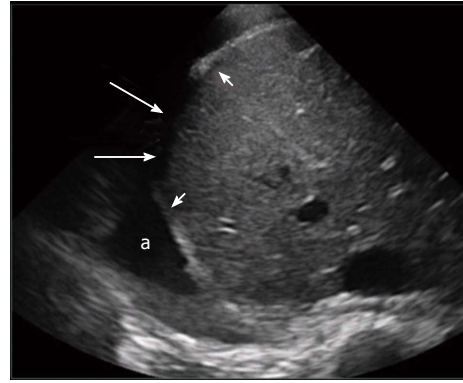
Sonographic findings in blunt diaphragmatic lesions. This transversal ultrasound scan directly shows the ruptured right hemidiaphragm (arrows) surrounded by thickened diaphragm edges (arrowheads). A good acoustic window is present due to a large pleural effusion (a).
